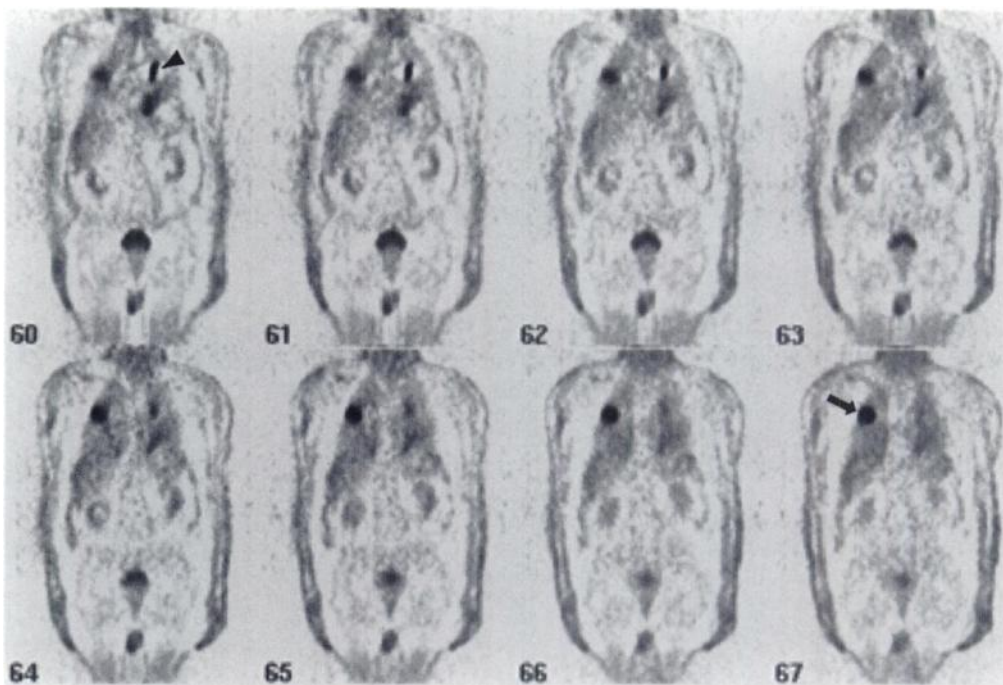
Eight sequential coronal whole-body FDG PET images show a large area of increased uptake in the right posterior upper lung (arrow). There is also an area of increased FDG uptake compatible with the patient's known malignancy in the left anterior upper lung (arrowhead). SUVs of lesions were 4.9 and 5.4, respectively.
